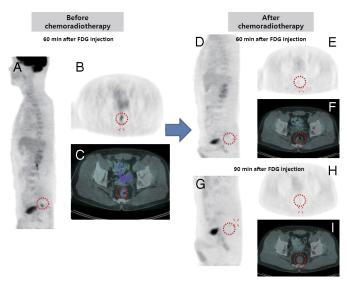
Representative case of a TRG4 pathological responder that was correctly classified with postSUV or RI as well as DI. Maximum intensity projection images (A, D, and G), transaxial images of PET (B, E, and H), and fused PET/CT (C, F, and I) are shown. (A, B, and C) Before neoadjuvant chemoradiotherapy, PET/CT scan showed focal tumor uptake in the rectum (red circles, SUVmax 4.8). (D, E, and F) After chemoradiotherapy, previous tumor uptake decreased to the almost background level on early phase PET/CT (red circles, SUVmax 1.0). (G, H, and I) On delayed phase PET/CT scan, no further FDG uptake increase was noted (red circles, SUVmax 1.0). Such an almost nonmeasurable lesion indicates complete metabolic response.
